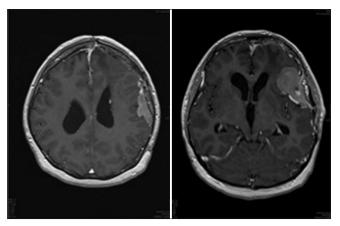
Follow-up MRI 3 months postoperatively, showing complete resolution of midline shift in axialTI view
